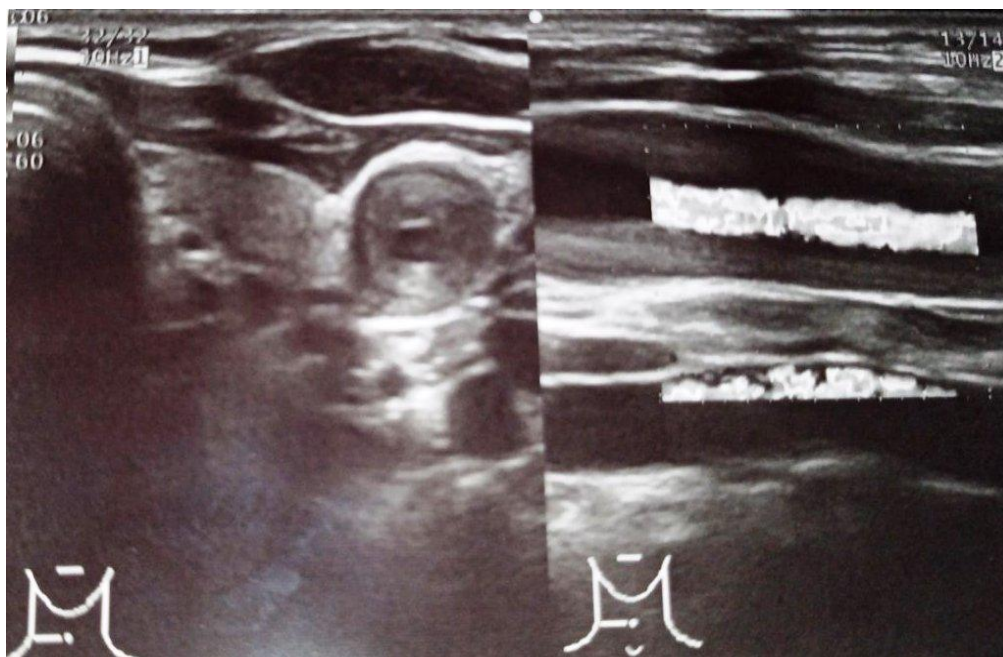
Ultrasonography of the left common carotid artery on transverse and longitudinal section – „Macaroni sign“
